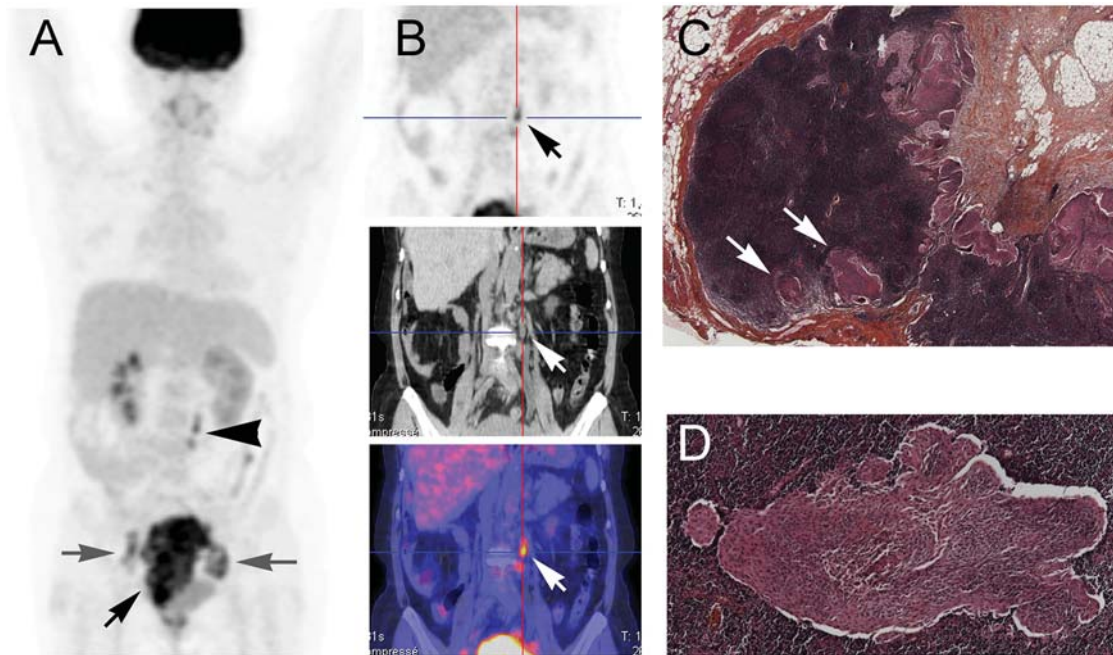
Paraaortic lymph node metastases of cervical squamous cell carcinoma, FIGO stage IIb. Cervical cancer (black arrow) with pelvic lymph node (grey arrows) and paraaortic lymph node (PALN) uptake (black head arrow) shown on anterior maximum intensity projection (MIP) view of FDG PET (A). PALN detected on FDG (black arrow, top), on CT (white arrow, centre) and fused data (white arrow, bottom) coronal slices (B). Squamous cell PALN metastases (white arrows) confirmed on pathological HES examination  $\times 25$  (C) and  $\times 100$  (D).
